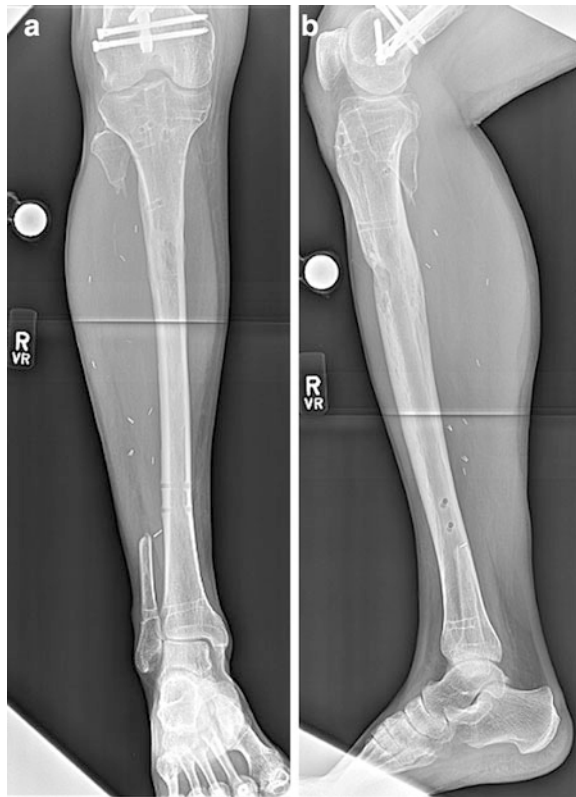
Final (a) AP and (b) lateral radiographs of right tibia post-internal lengthening nail removal. Note healed regenerate and maintenance of coronal and sagittal alignment. Four-centimeter lengthening was achieved
